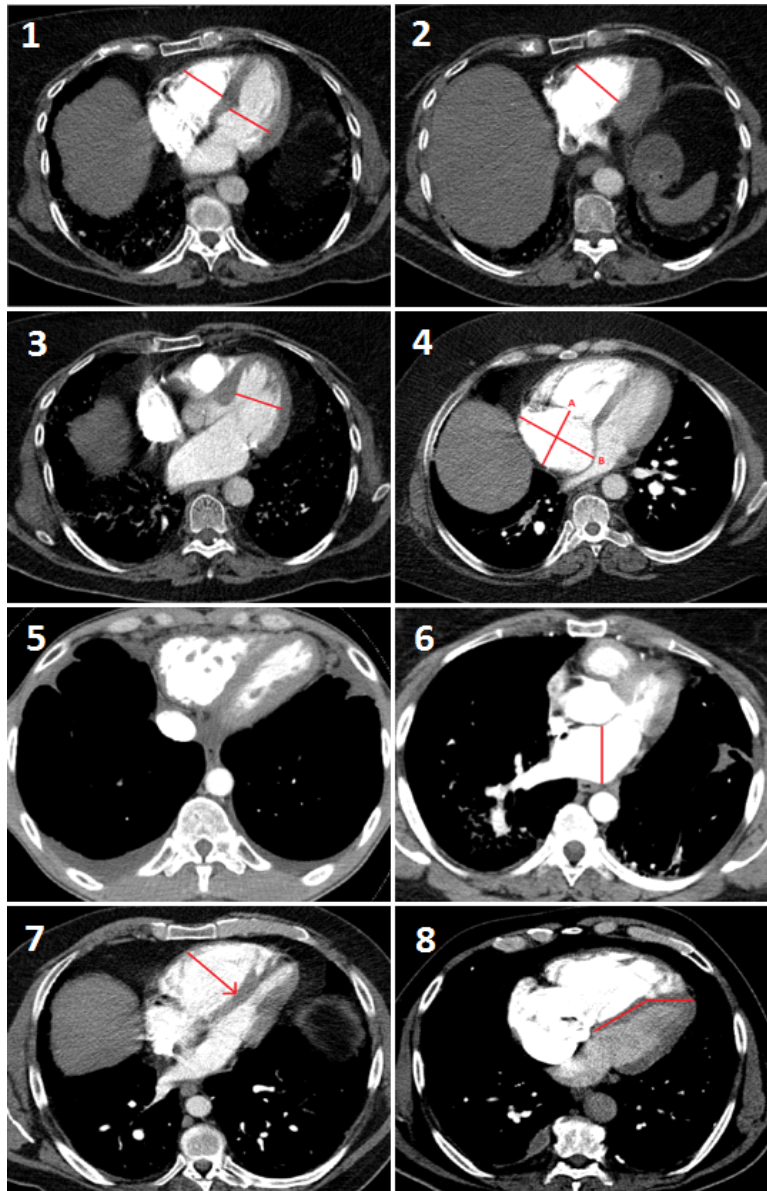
Measurements performed at CT pulmonary angiography
